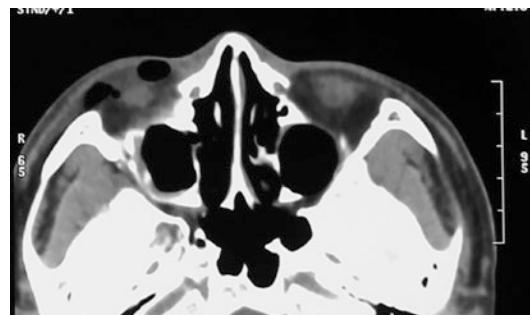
Postoperative horizontal orbital CT showed that orbital floor shape recovered and local emphysema (low-density area) occurred after fracture of the right infraorbital wall
